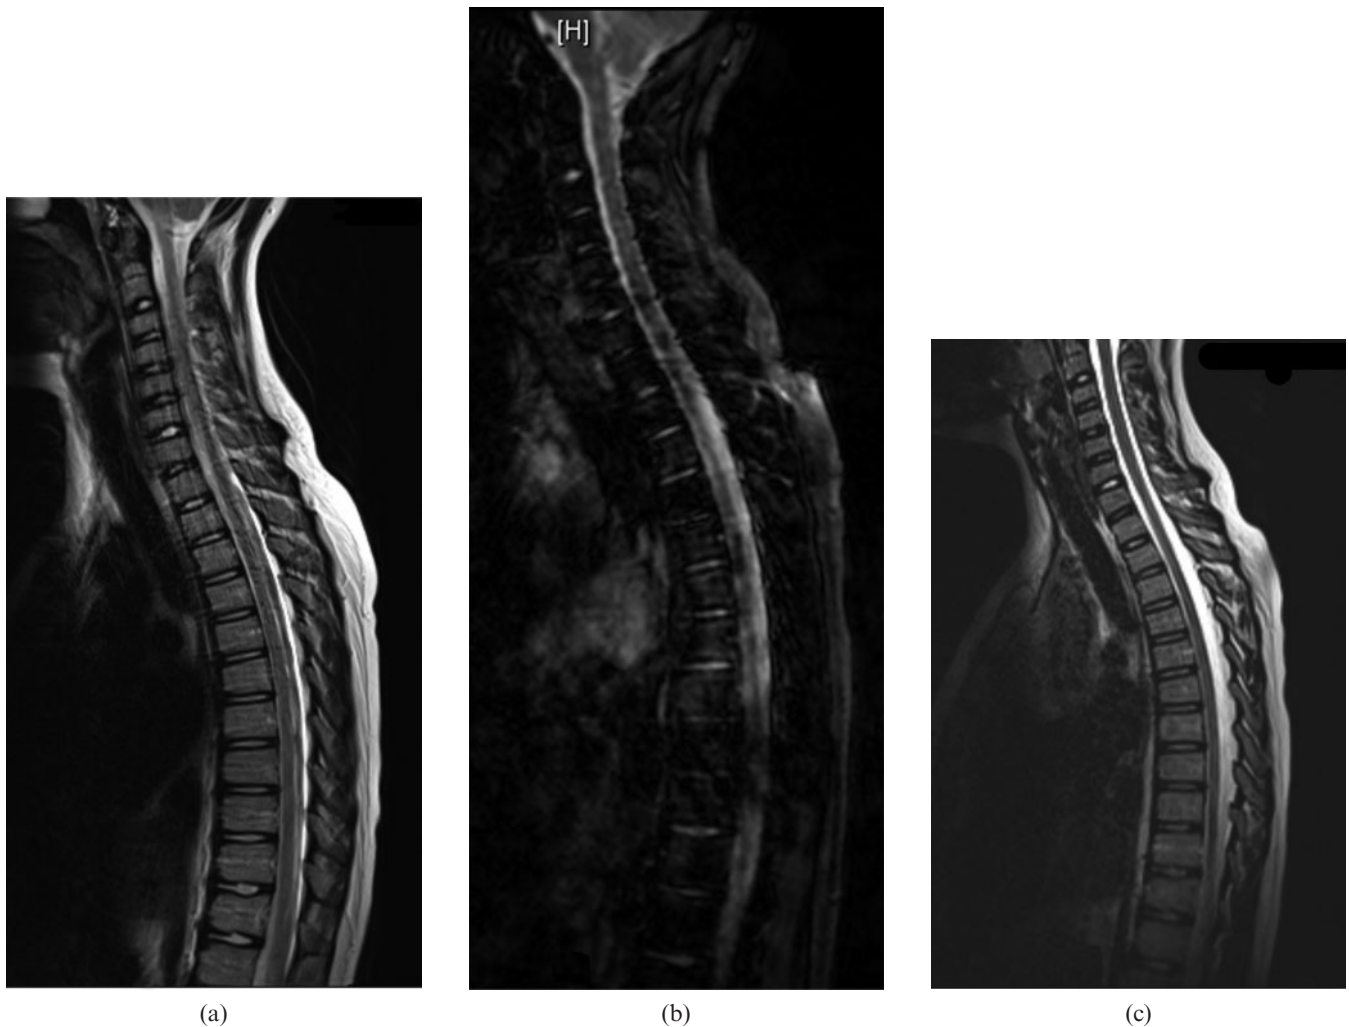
MR images of cervical and thoracic spine. (a) MRI of cervical and thoracic spine with significant flow and movement artefact on a conventional turbo spin-echo T_2 weighted sequence. (b) A gradient echo sequence yielded significantly worse images. (c) The 3D sampling perfection with application-optimised contrasts using different flip angle evolutions sequence results in sharp and artefact free images and is surprisingly resistant to most artefacts.
